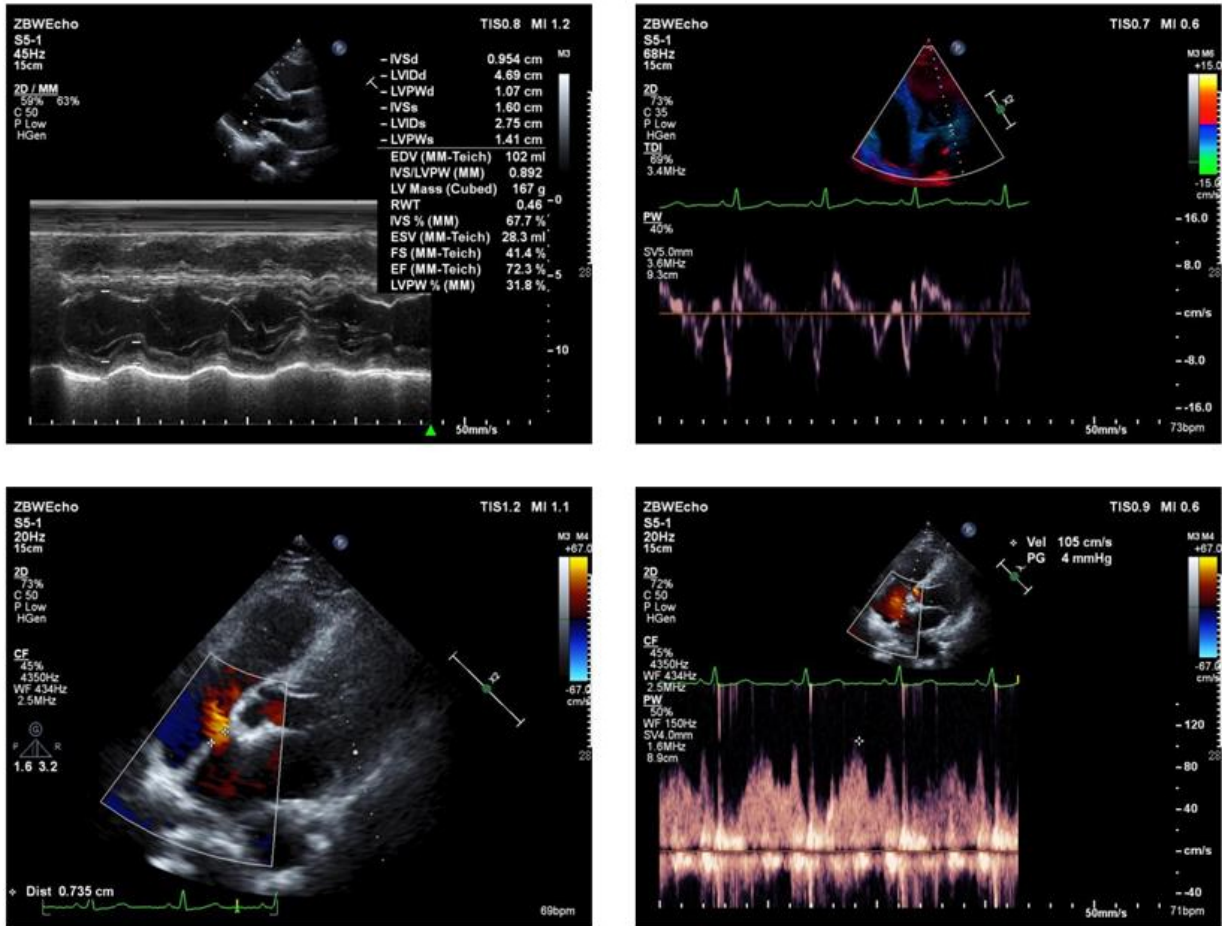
Preoperative echocardiography revealed atrial septal defect.
